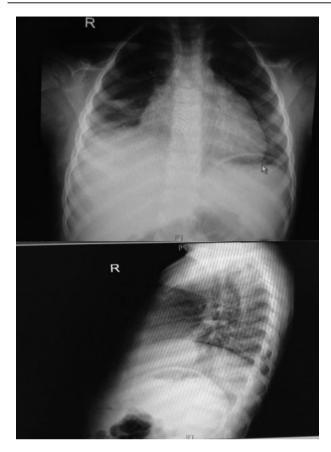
X-ray chest AP and lateral view showed persistent faint patchy opacity identified at the right lower zone with associated pleural thickening with possible effusion. Also noted is an irregularity along the right cardiac border likely related to right middle lobe opacity.
